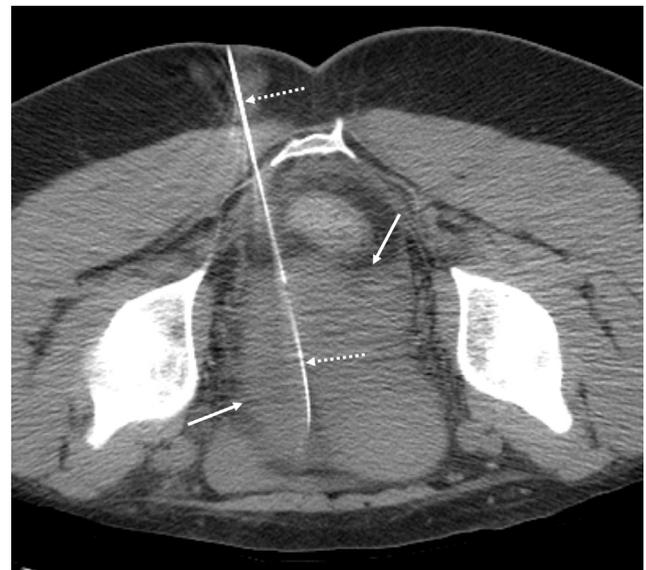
Prone axial CT image showing a hollow needle and traversing wire (dashed arrows) within the infected endometrioma (solid arrows).
